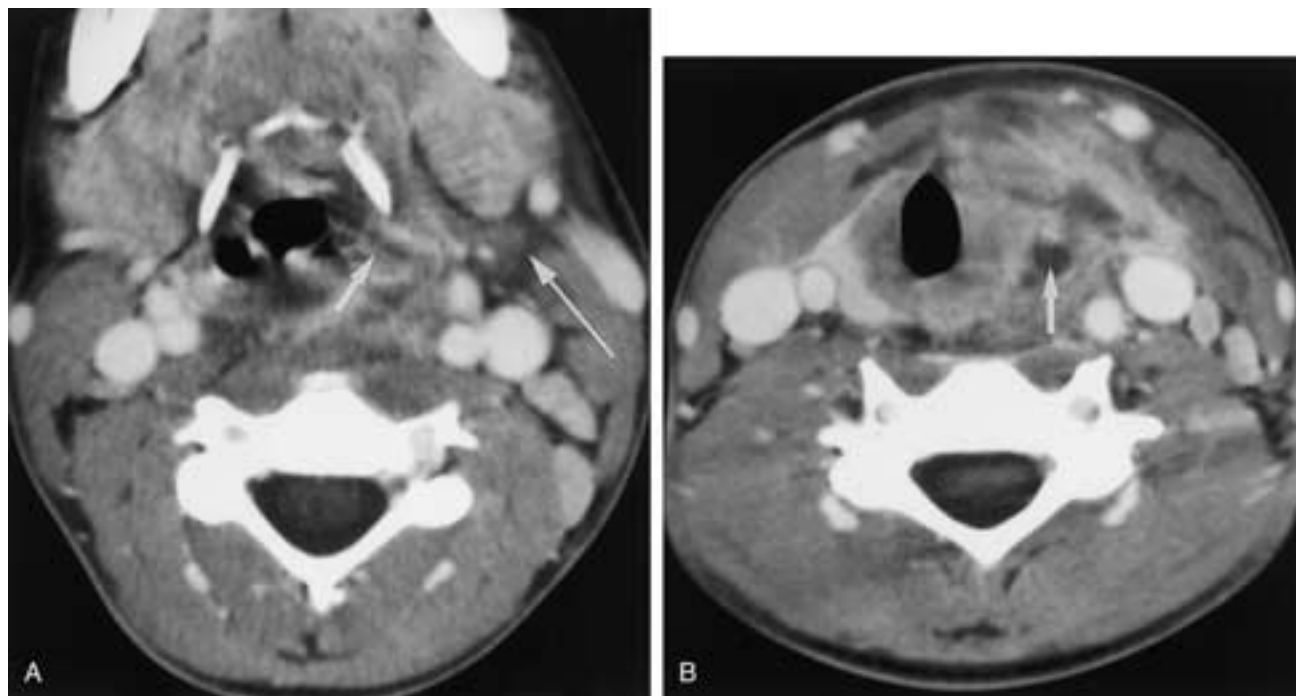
Pyriform sinus fistula in a 12-year-old girl with recurrent left perithyroidal suppurative infections. A, Contrast-enhanced CT shows effacement of the left pyriform sinus, with thickening of the mucosa (*short arrow*) and low-attenuation cellulitis of the left neck (*long arrow*). B, The left neck is swollen, the trachea is displaced to the right, and there is a small abscess (*arrow*) abutting the superior pole of the left lobe of the thyroid gland, with extensive surrounding inflammatory change. Several weeks after treatment and following resolution of inflammation, a pyriform sinus fistula was identified on an esophagogram.
